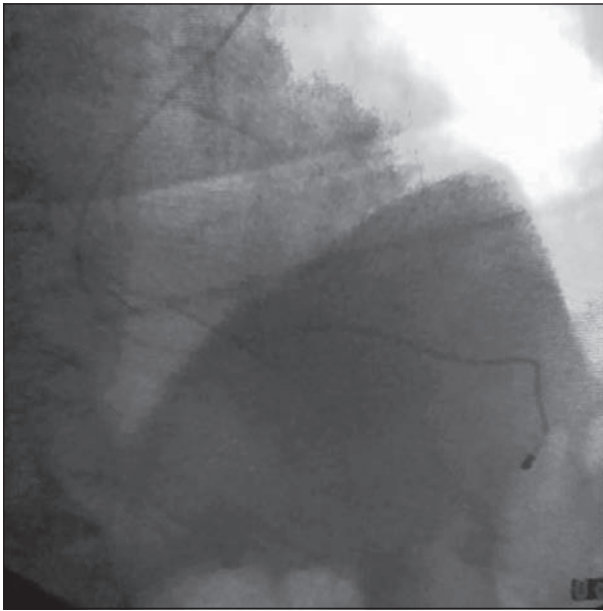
PA chest radiography: lead in coronary sinus (posterior branch)
